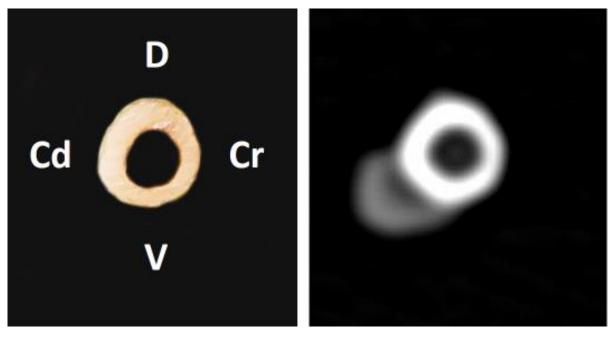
The cross-sectional view of right radius (photograph and CT scan)
